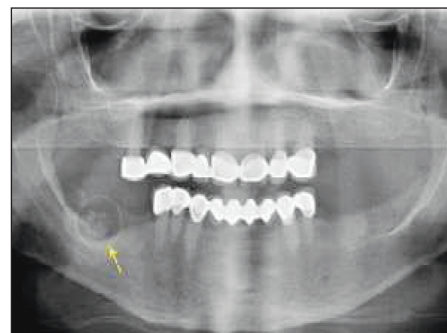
Panoramic radiography showed the affected area.
